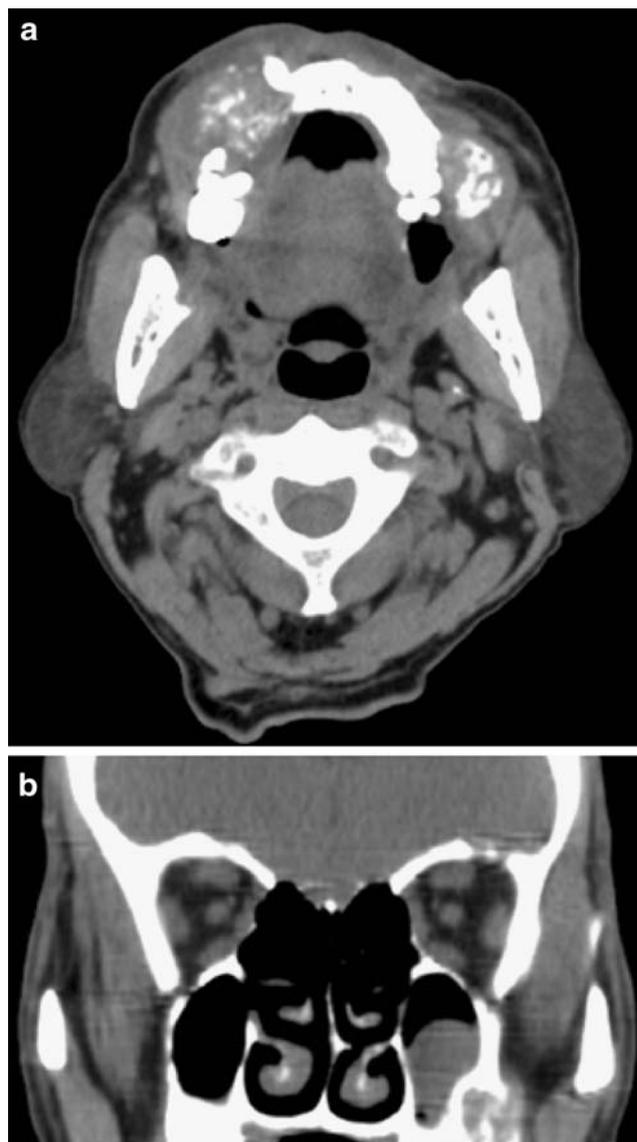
a and b The CT scan shows two large expansile lucent lesions at the alveolar process of the right and left maxilla with multiple hyperdense foci s/o calcifications cortex is expanded outwards with mild expansion of lingual surface on right side. Cortex is extremely thinned out and not visualised at places. The lesions are extending superiorly within the floor of the ipsilateral maxillary sinuses
